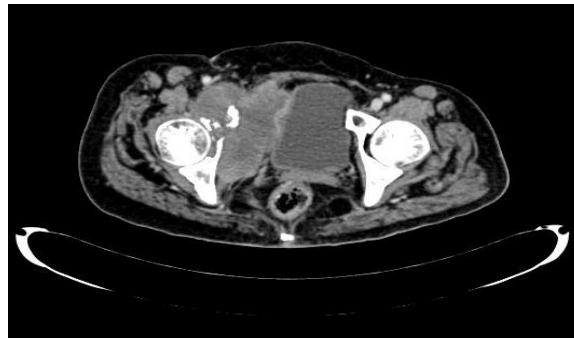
CT showing the lesion eroding the right acetabulum and right lateral wall of bladder.
